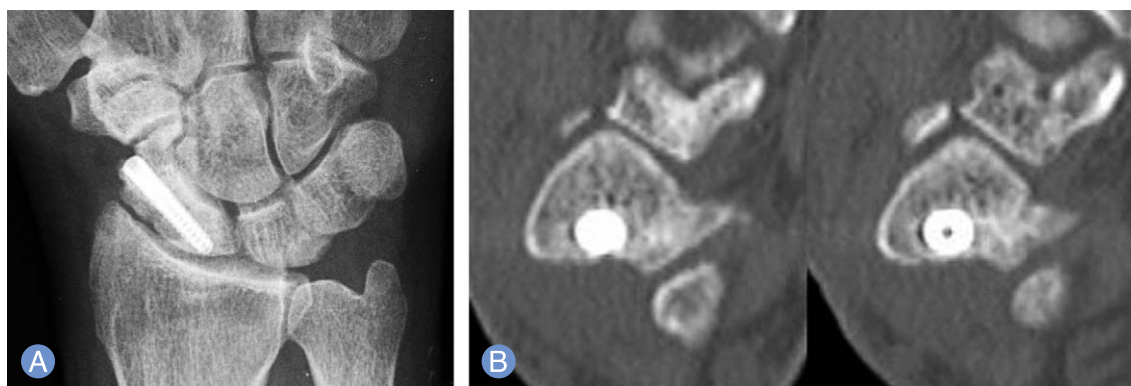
(A) One year after surgery radiographs showed union of scaphoid waist fracture. (B) on computed tomography scan, humpback deformity was corrected.
